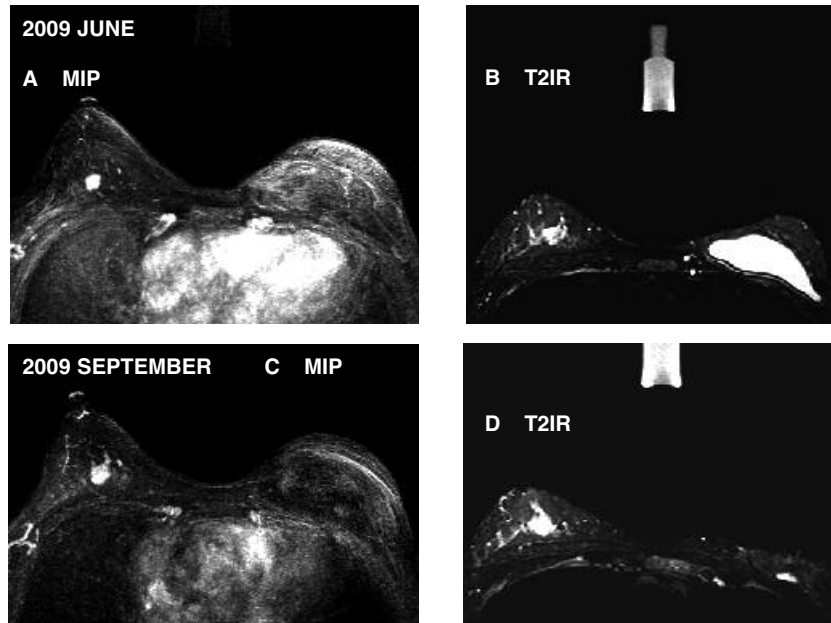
Patient no. 23. A) Multiplanar intensity projection (MIP) and B) T2 IR of June 2009. C) MIP and D) T2 IR at three recall. Forty-seven year-old patient, BRCA1 mutated, already submitted to left mastectomy for a previous invasive ductal carcinoma. A suspected mass-like enhancement was seen at first MRI (A); high signal intensity and irregular borders (B). Mammography and ultrasound both gave negative results the same day. The mammographic pattern was P1. Only 3 months later, MRI revealed both a significant volumetric increase (C) of the disease and the onset of two more small suspected foci next to the first lesion. The T2 signal intensity of the disease was very high (D). Mammography remained negative. Following the MRI report, ultrasound disclosed the onset of a nonhomogeneous area within the same quadrant. The major lesion was an invasive carcinoma; the smaller foci respectively belonged to a focus of IDC + ILC and to a complex mastopathy. The subject already been part of our diagnostic surveillance program for 7 years, but she had not undergone annual screening (her personal decision). The former MRI was dated 3 years before, when only a dysplastic pattern was detectable. However, even retrospectively, the cancer lesion had arisen in a region where no enhancement was observable on previous examinations.
